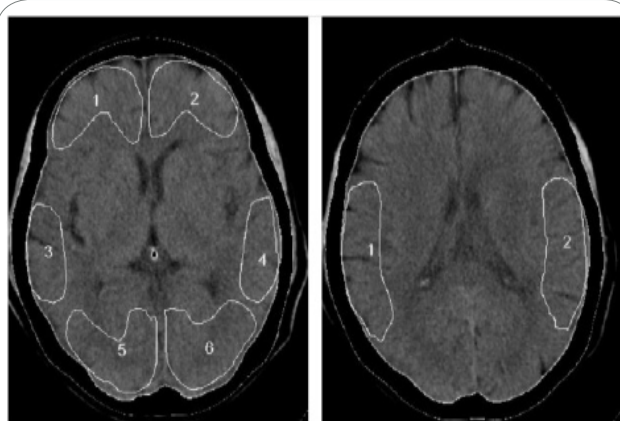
Sections analyzed on CT images. Slices 1 and 2 are axial images that include the basal ganglia and the temporo-parietal cortex, respectively. ROIs were selected on each image. Slice 1: The level of the analyzed slice passed through the basal ganglia and included the midsection of the anterior horns of the lateral ventricles, the caudate putamen, thalamus, and pineal body posteriorly. Three pairs of cortices corresponding to the frontal cortex (1 and 2), the temporal cortex (3 and 4), and the occipital cortex (5 and 6) were assessed. Slice 2: 1 and 2 represent the temporo-parietal cortex including the parieto-insular vestibular cortex (PIVC).
